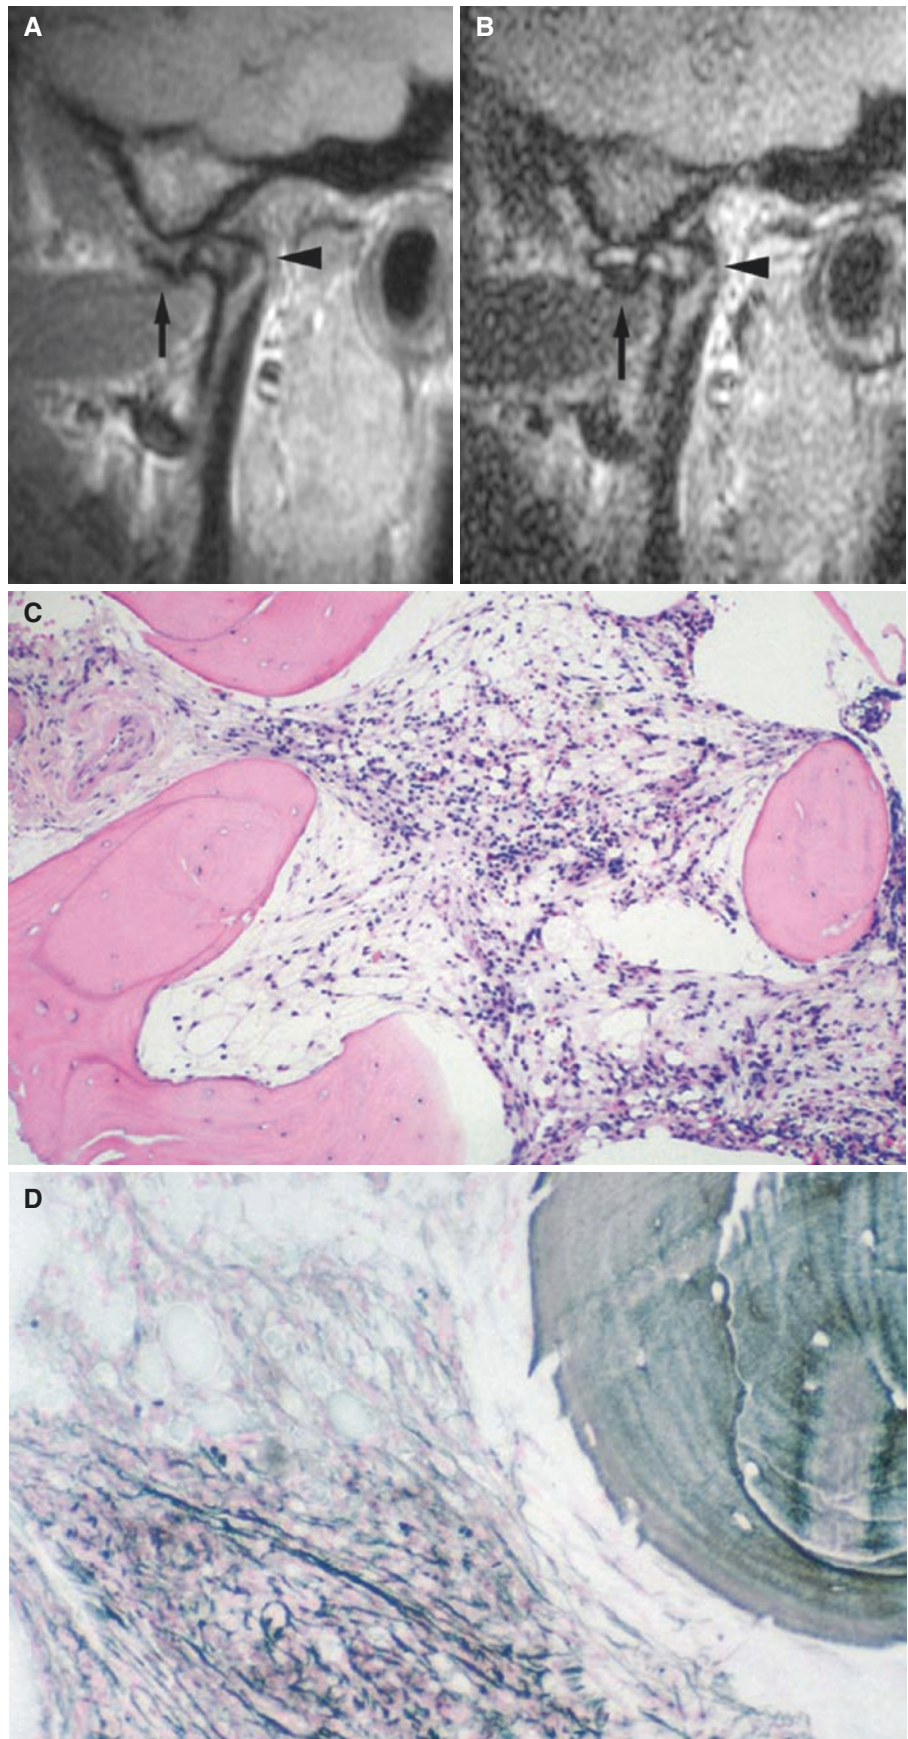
Osteonecrosis, anterior disc displacement, osteoarthritis, joint effusion. (A) Oblique sagittal MRI shows anteriorly displaced, deformed disc (*arrow*) and cortical irregularities of the condyle with reduced signal from condyle marrow (*arrowhead*). (B) Oblique sagittal T2-weighted MRI shows effusion in the entire upper compartment
